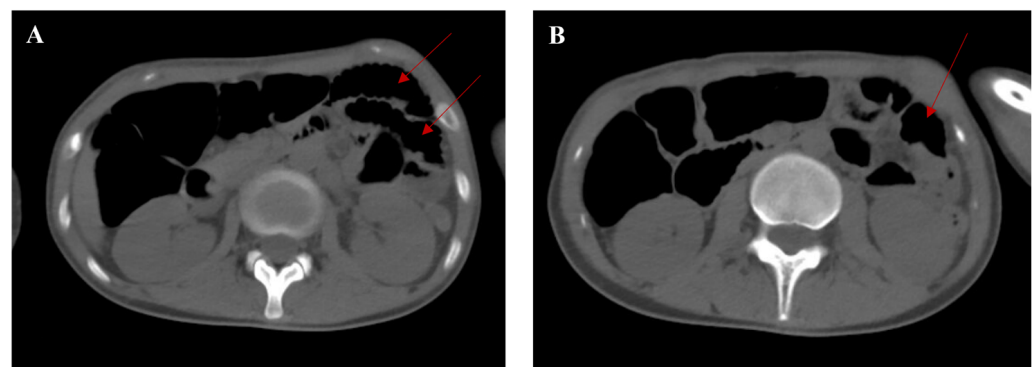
Non-contrast abdominopelvic computed tomography (CT) findings of the patient (on 29 May 2025). (A) The CT image shows dilated small bowel loops (red arrows) in the left upper quadrant, lateral to the splenic flexure of the colon. (B) The CT image at a lower level shows the dilated small bowel loop (red arrow).
